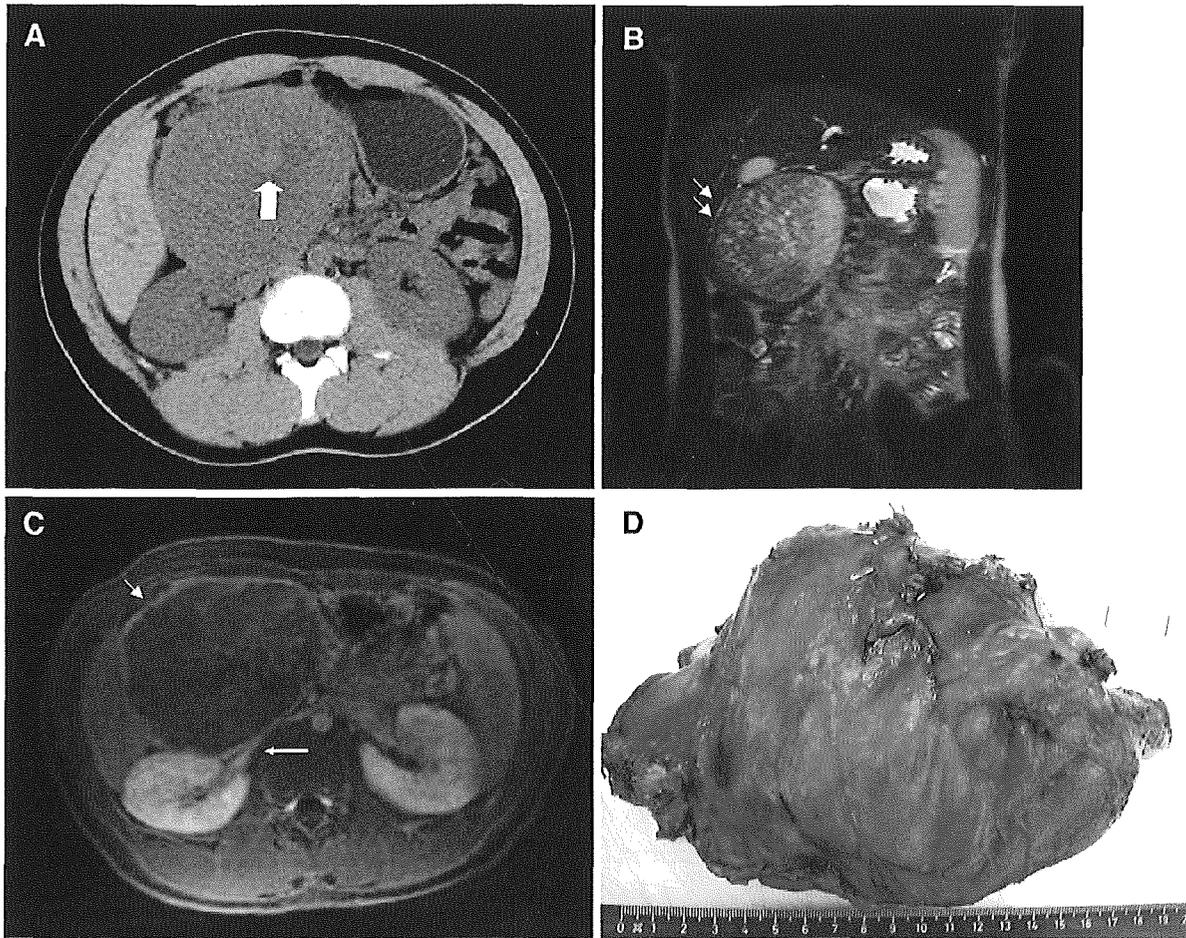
Case 2. (A) Native CT scan reveals a well-defined encapsulated mass with hyperdense central hemorrhage (solid arrow). (B) Coronal T2-WI MRI reveals the heterogeneous character of the tumor of the well-delimited mass. Observe the high degree of compression of the gastric outlet and the duodenum (double arrow). (C) Axial T1-WI MR after intravenous injection of contrast agent shows enhancement of the tumor's pseudocapsule (arrow) in an otherwise hypovascular tumor. Observe the compression of the right renal vessels. (D) Macroscopic view of duodenopancreatectomy, including the voluminous mass at the head of the pancreas.
